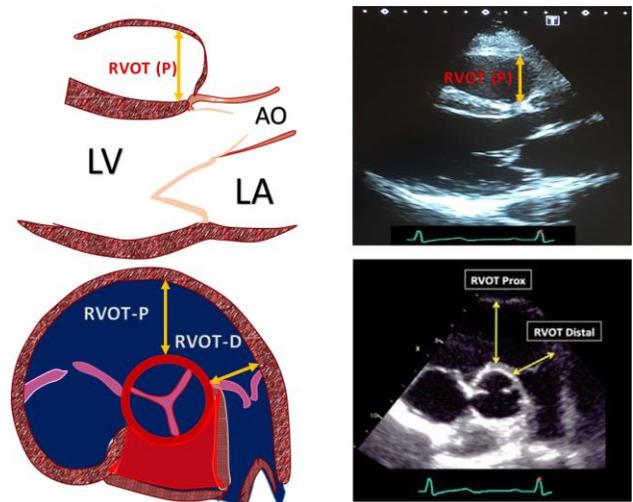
Parasternal Long and Short Axis views. Yellow lines show the dimensions of proximal and distal RVOT.
